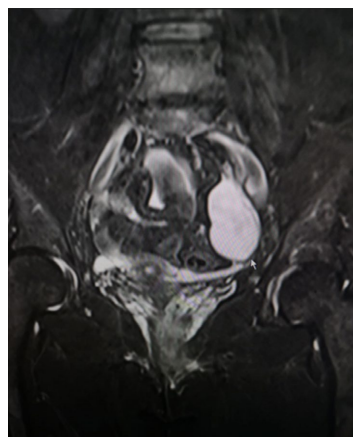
Coronal T2-weighted magnetic resonance imaging of the left ovarian hemangioma.
